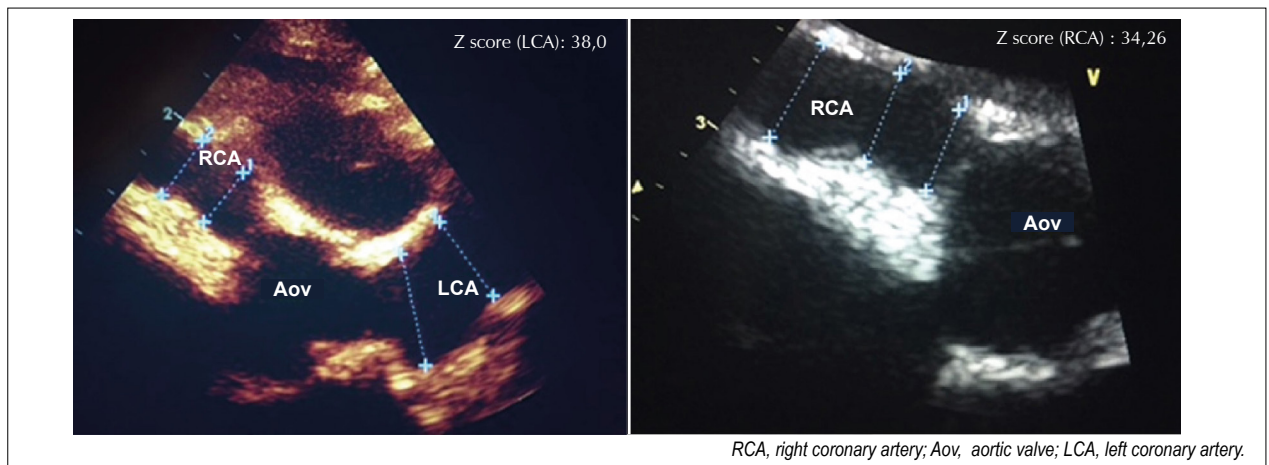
Transthoracic echocardiogram taken in the transverse short-axis plane showing the giant right and left coronary aneurysms and the respective Z scores in an infant with Kawasaki disease diagnosed at six months of age.
